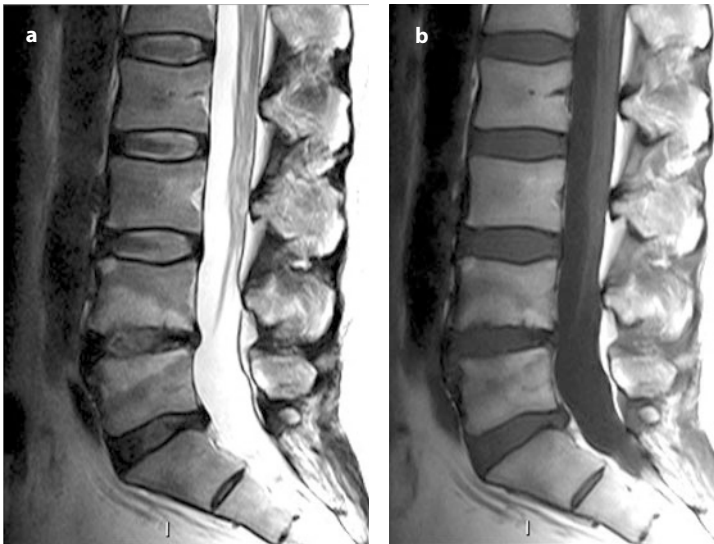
Anterior osteocondrosis of the L4–L5 disk space as shown on MRI. a T2-weighted image shows intense hypersignal of the endplates and adjacent bone marrow, compared to the T1-weighted image (b), that shows prevalence of hyposignal; this indicates a prevalence of Modic 1 modifications (inflammatory) with a less intense Modic 2 component
